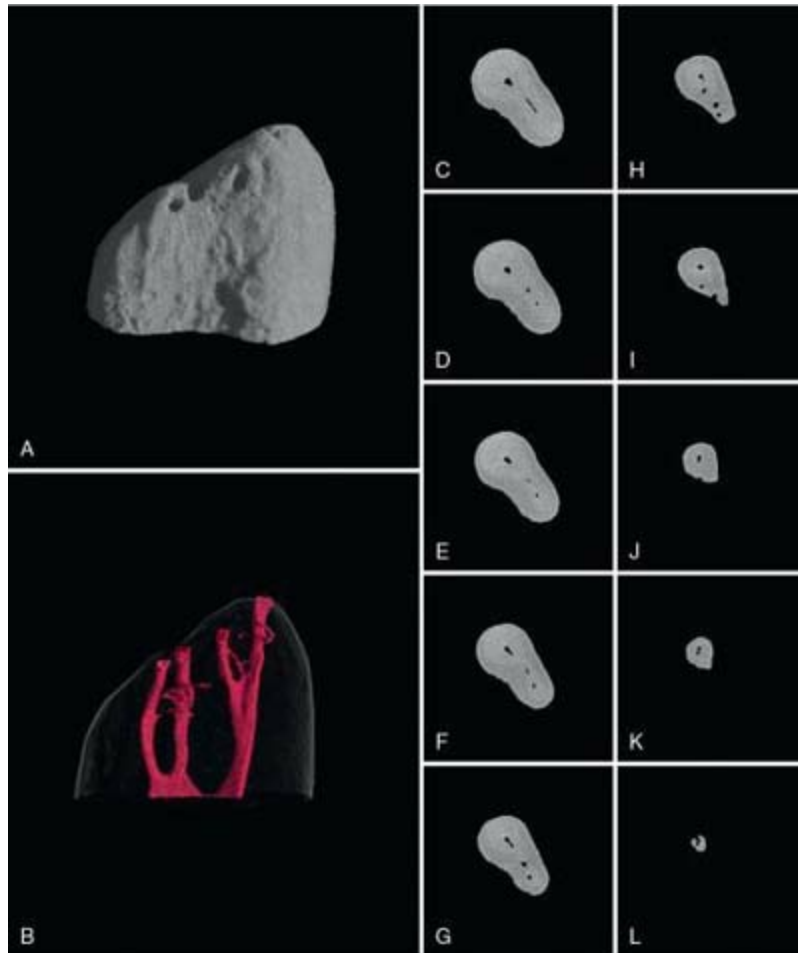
Microcomputed tomographic scan of anatomy of the apical 5 mm of a mesiobuccal root (8 μ m resolution). A–B, Three-dimensional reconstruction of outer contour and root canal systems. C–L, Cross sections 0.5 mm apart.
